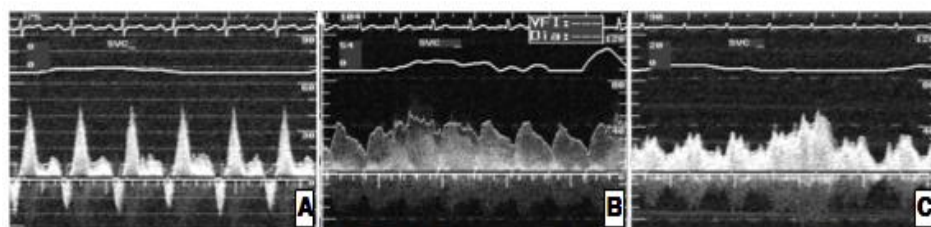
Intravascular Doppler spectrals at SVC in 3 groups (A;APC group, B;LTF group, C;ECF group)
